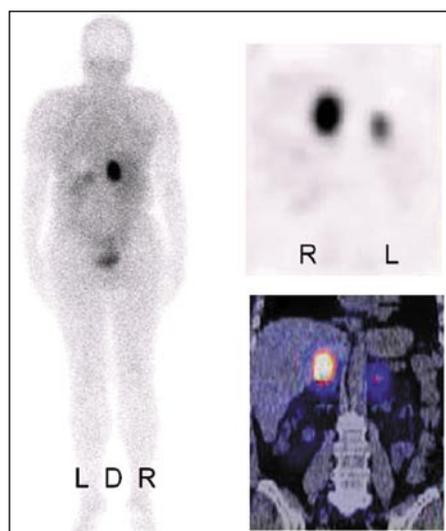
58 year old patient with right sided adrenocortical adenoma: Five hours after administration of 184 MBq $[^{123}\text{I}]\text{Iodometomidate}$ a strong accumulation of the radiotracer is observed in the right adrenal gland (left: planar whole body scintigraphy in a dorsal projection; right: SPECT & SPECT/CT).
